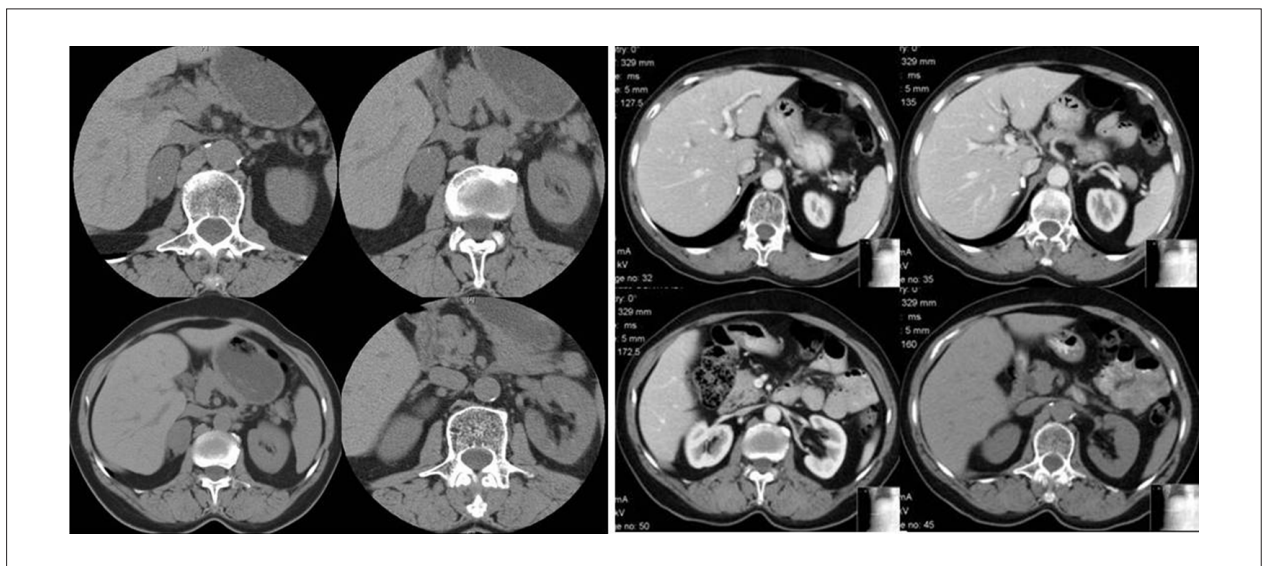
Abdominal CT: formation in the right adrenal gland, with discrete calcifications (on the left) and absence of recurrence six months after surgery (on the right).
